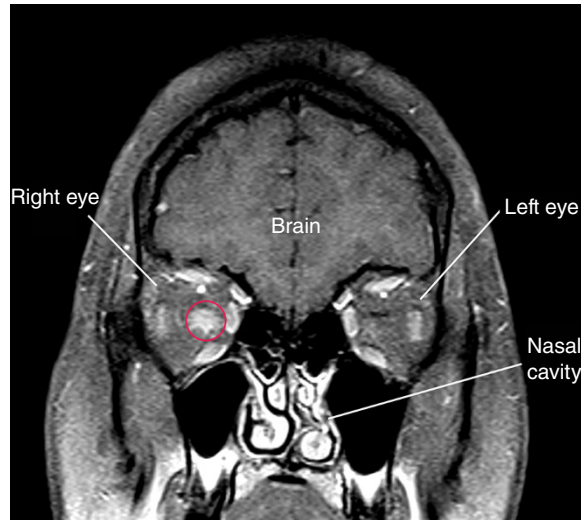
Coronal MRI of a 20-year-old patient who showed progressive loss of vision in the right eye over the last several weeks. The patient was eventually diagnosed with MS. The white area within the red circle represents inflammation of the optic disc/nerve. The swollen right optic nerve (circled) is quite obvious compared to the invisibility of the left nerve on the image.
